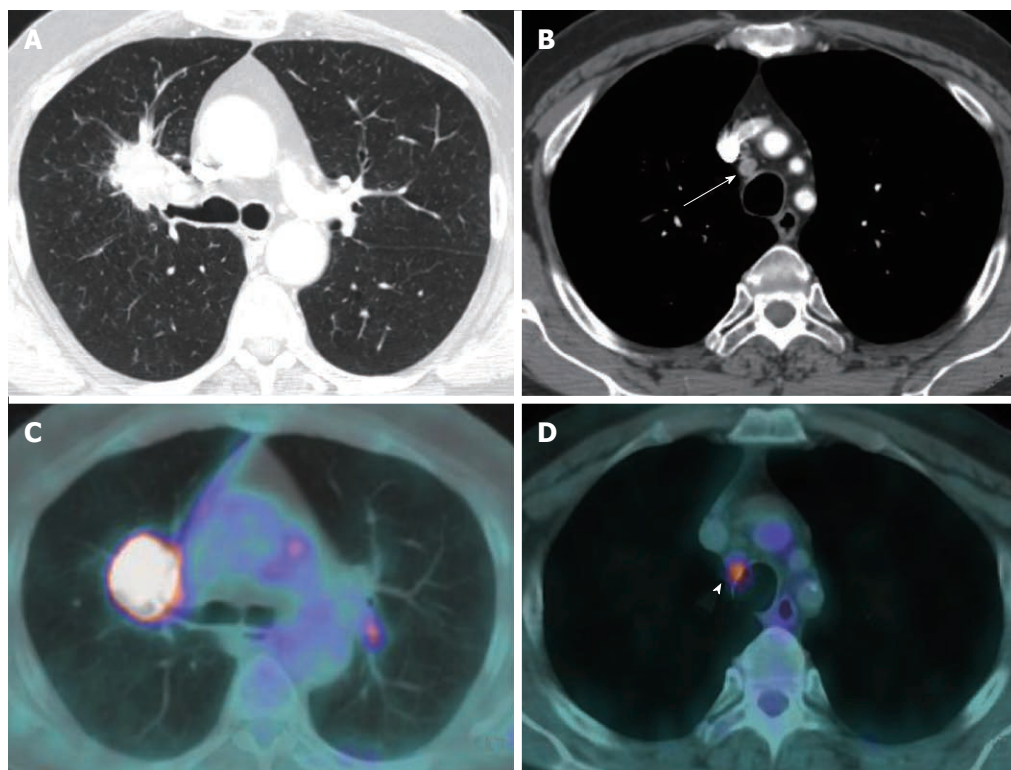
Contrast enhanced thoracic computed tomography viewed with lung window settings shows a 5.2 cm ill-defined mass suspected of lung cancer abutting the right lung hilum, causing narrowing of the upper lobe bronchus (A). B: Review of images on mediastinal window settings showed a paratracheal lymph node with short axis smaller than 1 cm (arrow) in station 2R; C and D: Positron emission tomography-computed tomography demonstrated a high [18F]-2-fluoro-2-deoxy-d-glucose-uptake of both mass and 2R node (arrowhead), resulting in an up-staging of the disease from T2bN1 (CT classification) to T2bN2. This finding was further confirmed by mediastinoscopy sampling.
